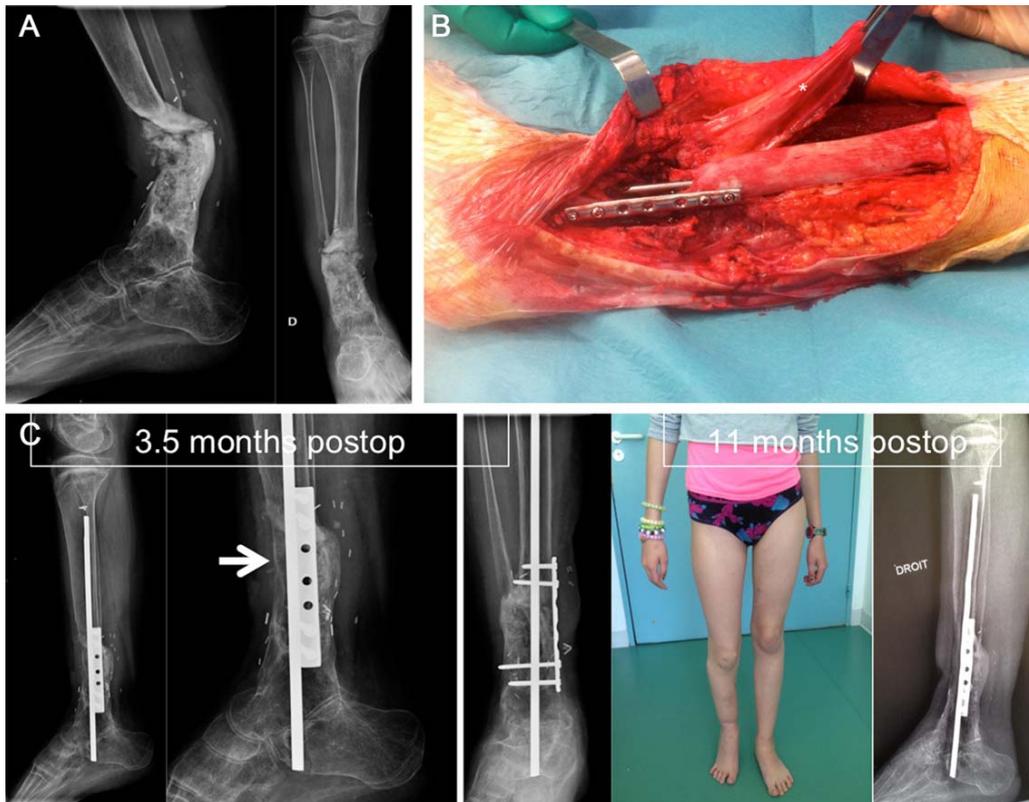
A: Distal-third tibial nonunion following a segmental bone defect reconstructed with an induced membrane technique. B: VTPG (*) harvested from the proximal tibia (+) and pedicled distally to cover the anterior part of the debrided nonunion focus. No bone graft was added. C: Radiographs showing a complete bone healing 3.5-months after surgery with an anterior bone callus formation (arrow). Full weight bearing was allowed afterwards uneventfully with no reported complications 11 months after the surgery. Preoperative equinus deformity partially compensated a 4 cm limb length discrepancy. Eleven months postoperatively the radiographs showed a complete callus ossification and remodeling.
